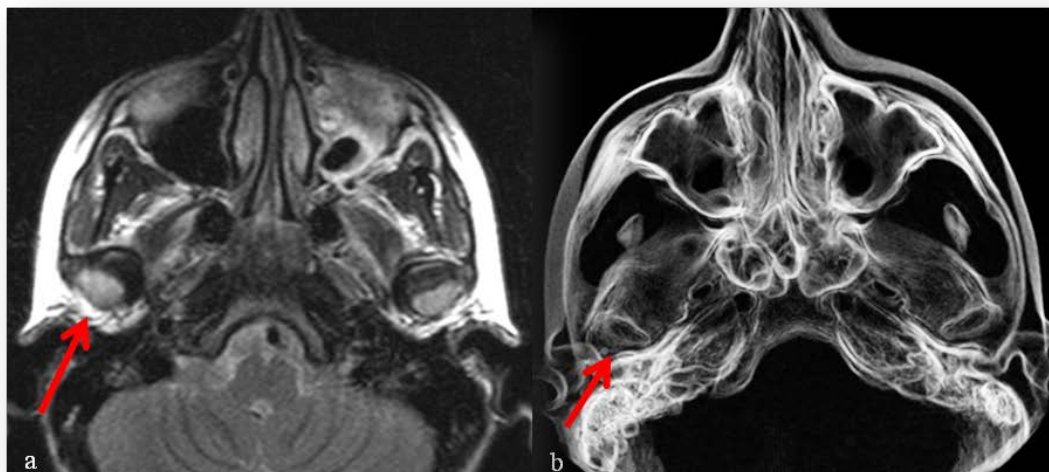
A 10-year-old girl with oligoarticular juvenile idiopathic arthritis without systemic treatment. This patient is in inactive phase. According to the report from the MRI specialist, both TMJs are similar, affected with anterior disc displacement in closed month. a) Note the presence of synovial enhancement in the corresponding axial fat-saturated postgadolinium T1-weighted image of both TMJ. It is also seen a slight irregularity in the condylar shape. b) CBCT view after the application of our EPF. The arrow describes the same anatomical position in both images.
